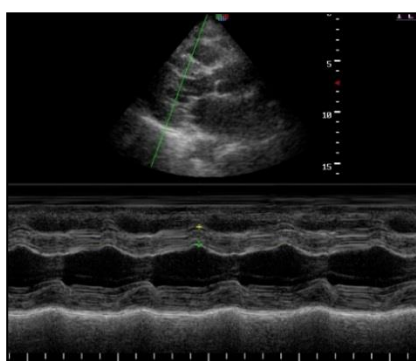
M mode echocardiography of LVH
